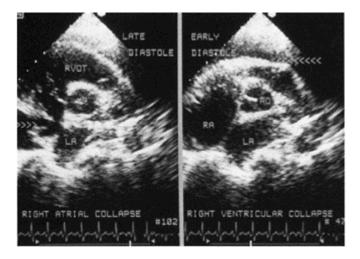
Short-axis, two-dimensional echocardiogram through the base of the heart in a patient with pericardial effusion and cardiac tamponade. Late diastolic right atrial collapse (left panel) and early diastolic right ventricular collapse (right panel) are noted as indentation of the two walls. Ao: aorta; RA: right atrium; LA: left atrium; RVOT: right ventricular outflow tract.
